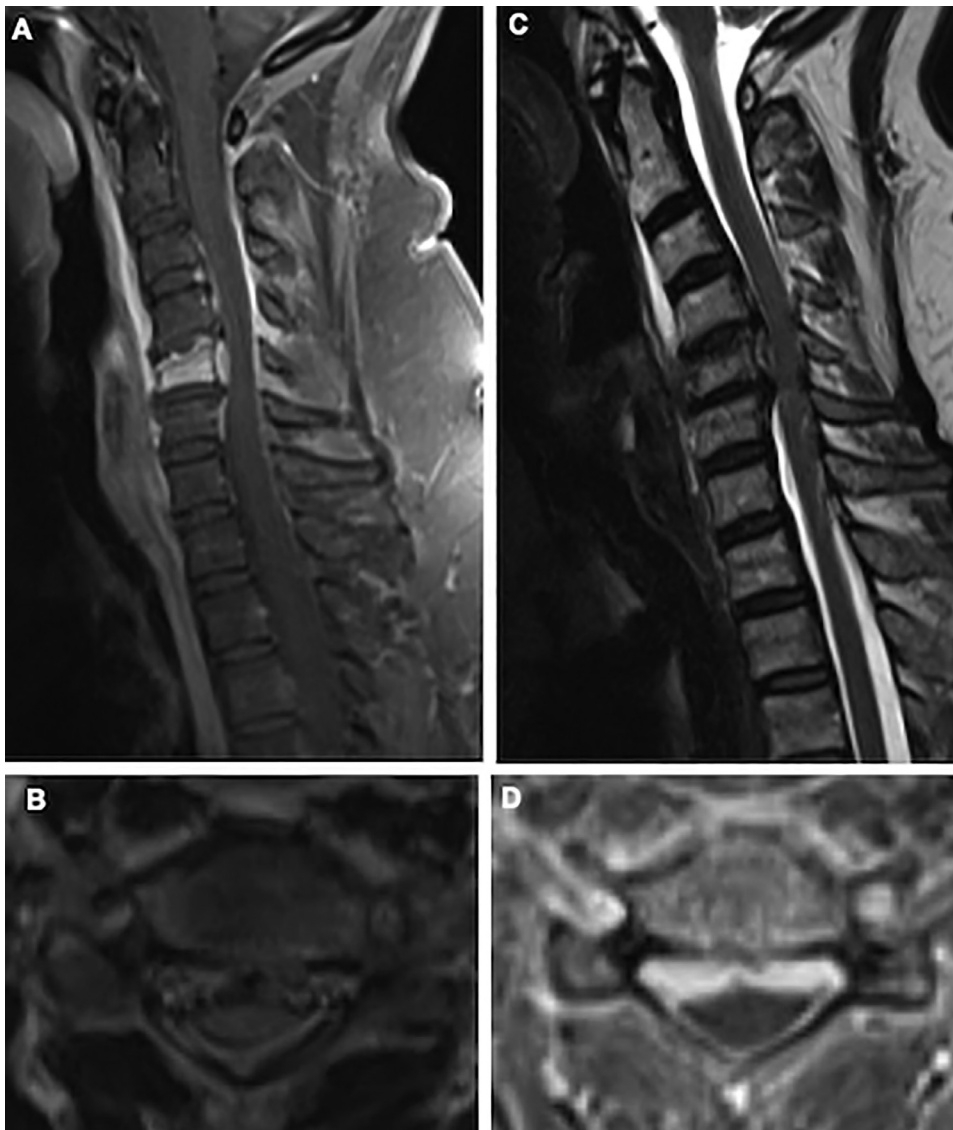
Panel A shows a T1-weighted contrast enhanced sagittal image, Panel B shows a T2-weighted axial image at C5 level, Panel C shows a T2-weighted sagittal image, and Panel D shows a T1-weighted contrast enhanced axial image at C5 level demonstrating the C5 compression deformity with moderate spinal canal stenosis at that level, and prevertebral enhancement anteriorly from C2–5 and epidural enhancement posterior to the C5 vertebral body.
